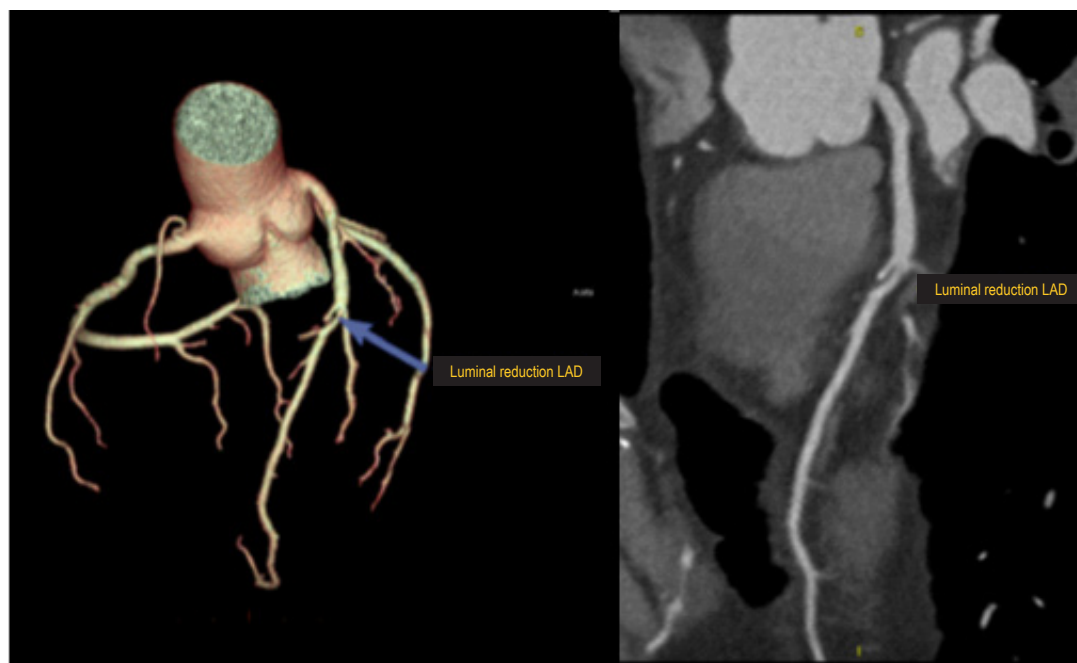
Case 9 - Angio-CT demonstrating significant obstructive luminal lesion, with the absence of calcification in coronary arteries. LAD left anterior descending artery.
